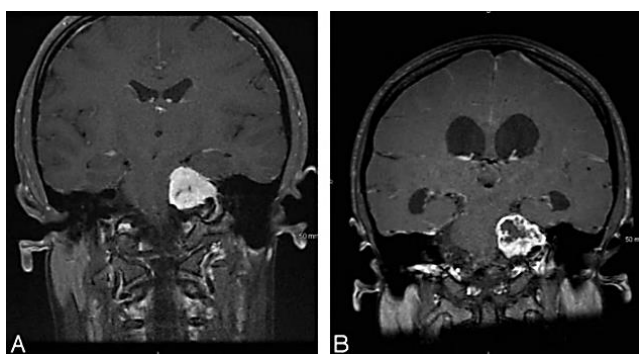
T1-weighted MR imaging after gadolinium (A) 14 days before and (B) 36 weeks post procedure image.
